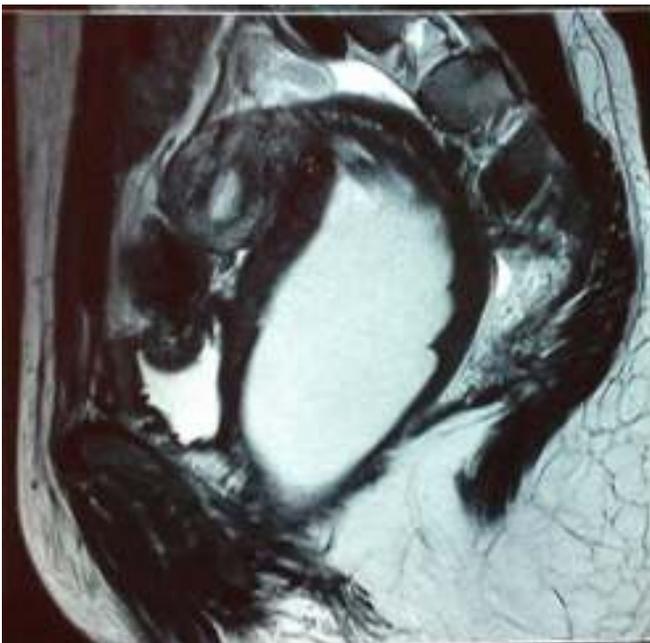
Sagittal veiw of hematocolpos on Magnetic Resonance Imaging
